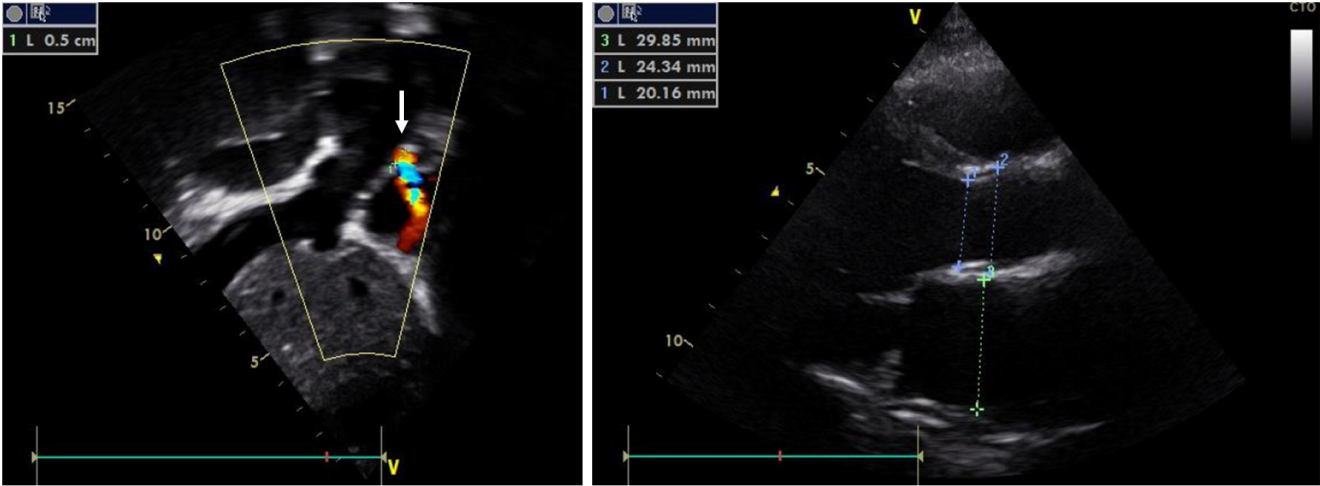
Transthoracic echocardiogram. A Sub-external axis showing right to left shunt from the Fontan fenestration (0.5 cm) to the right atrium (white arrow) B. Long sternal axis showing left ventricle dilatation without evidence of infective endocarditis.
